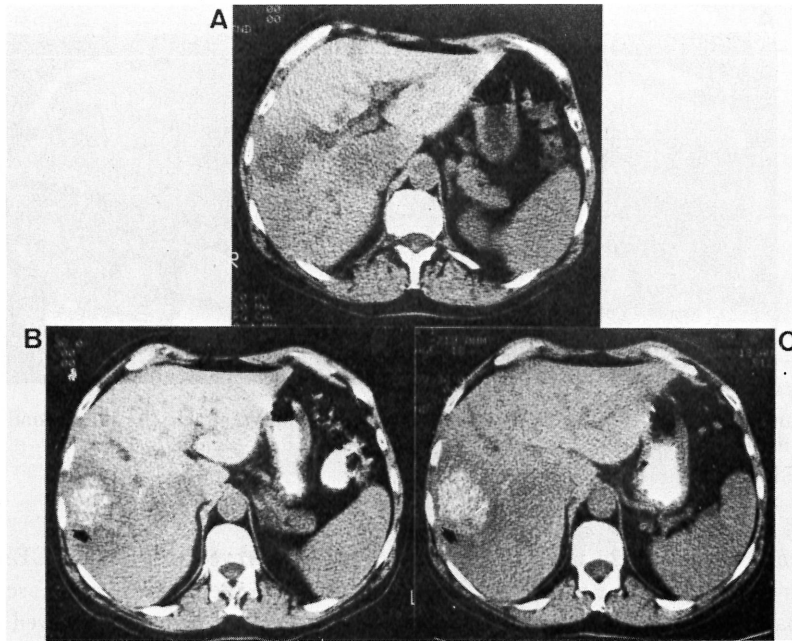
CT scans of patient 3 with hepatic metastases before treatment (A) and 1 month (B) and 2 months (C) after treatment. Presence of increased calcification is indicated by *arrow*.
